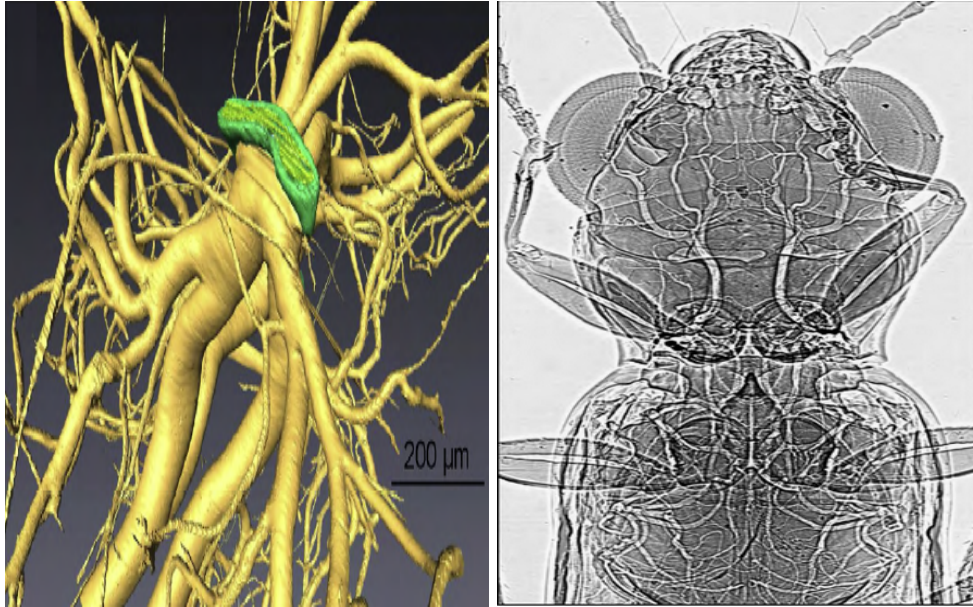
Tracheal system and synchrotron x-ray image of the tracheal system of a carabid beetle (Socha *et al* (2010) [61]).
